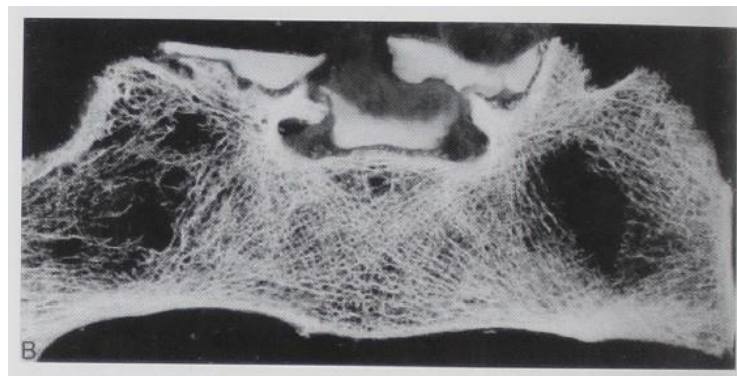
Axial section of an adult sacrum scanned by CT showing dense trabeculae in S1 body and sparse trabeculae in the ala regions (modified from Peretz *et al*, 1998).
